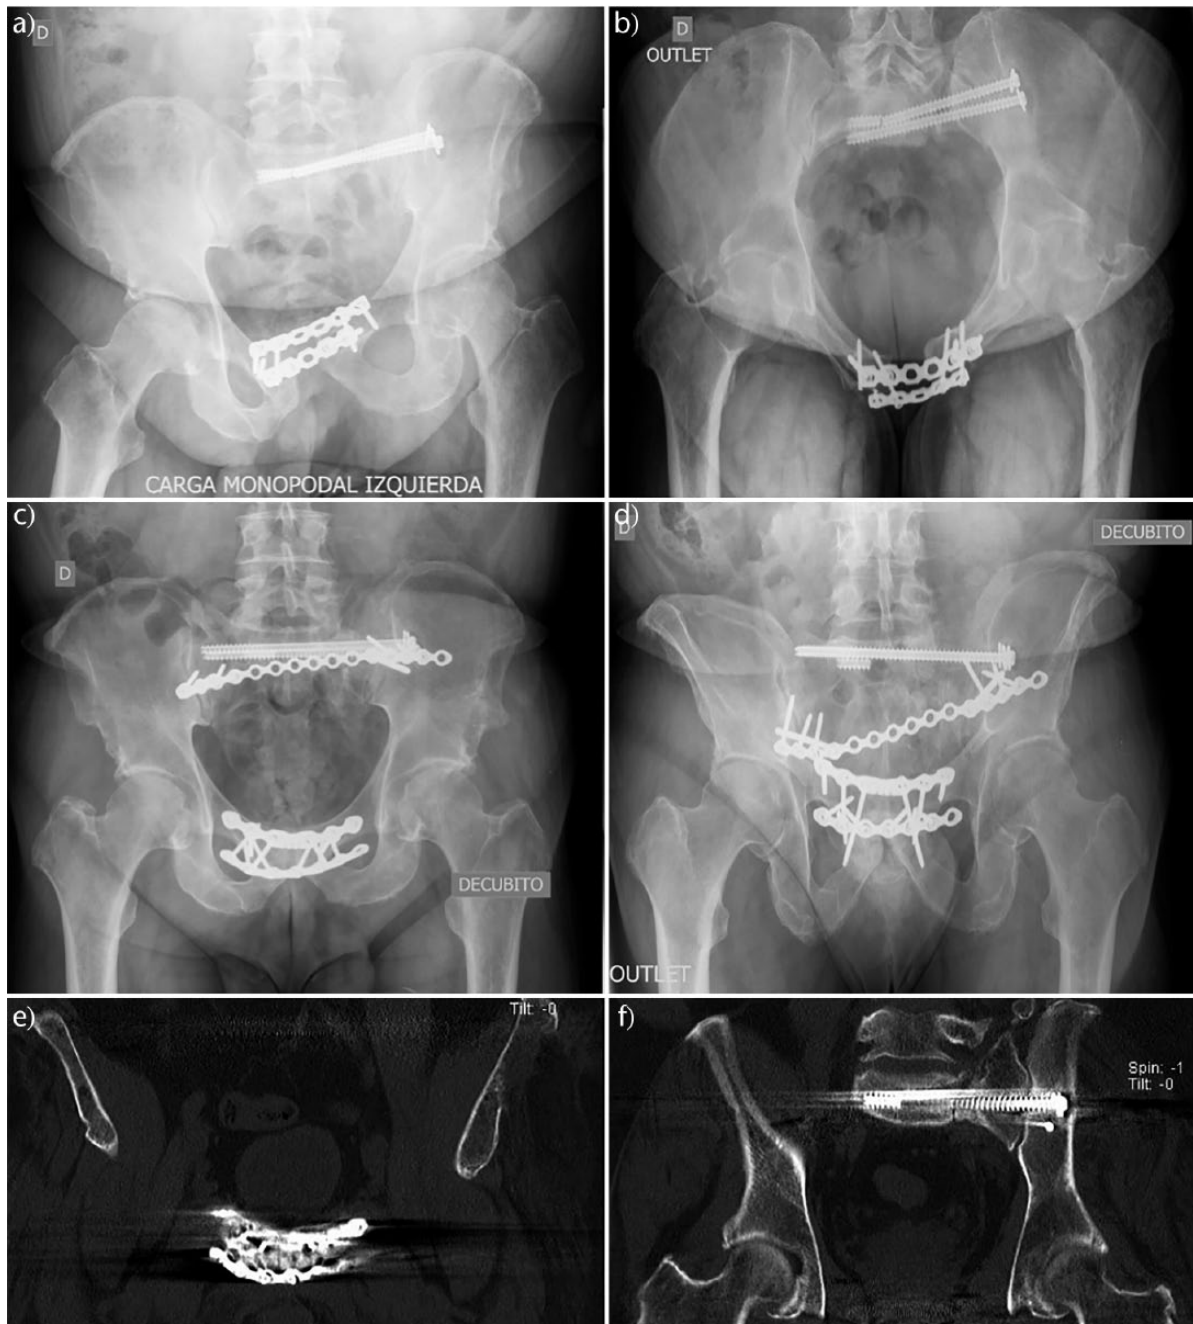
Type II complex instability with associated deformity and nonunion: a) and b) preoperative radiograph; c) and d) postoperative radiograph (sequential liberation surgery, correction of the deformity, posterior arthrodesis and anterior arthrodesis); e) and f) coronal CT scan.
